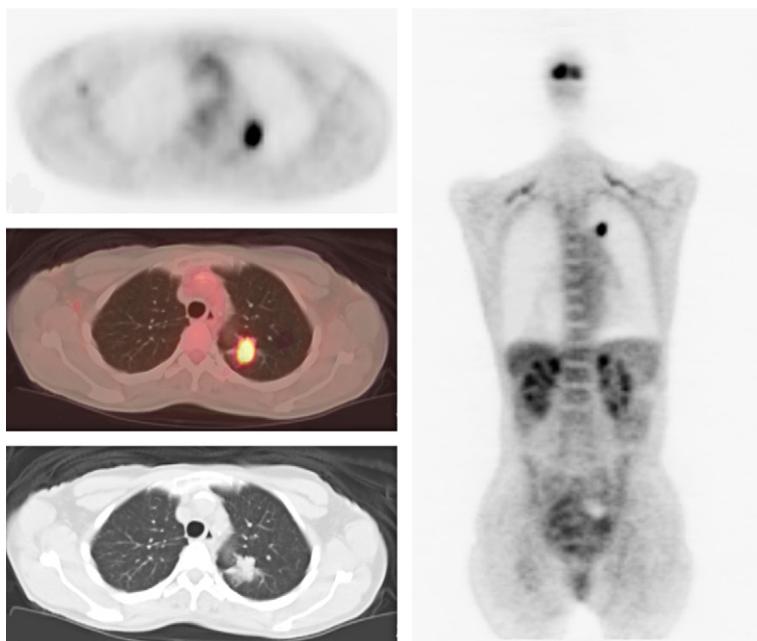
A 65-year-old woman with lung nodule for evaluation. FDG-PET scan showed increased uptake in a nodule in the left upper lobe consistent with malignancy. Biopsy demonstrated poorly differentiated adenocarcinoma.
